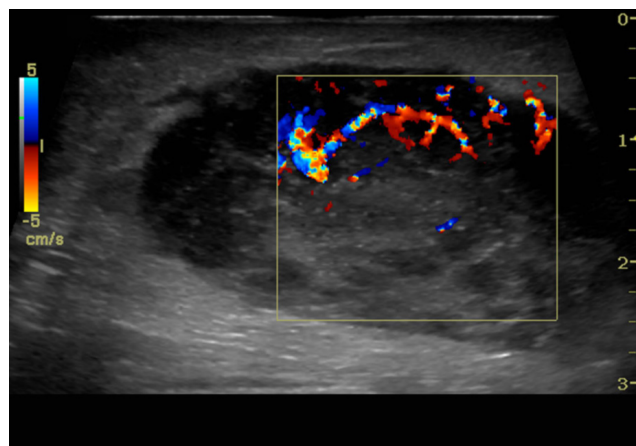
75-year-old woman with primary breast lymphoma. Ultrasound image of the palpable area demonstrates a 44 x 20 x 44 mm heterogeneous, hypoechoic oval mass parallel to the chest wall with circumscribed and microlobulated margins and increased vascularity at 1 o'clock 3 cm to the nipple.
